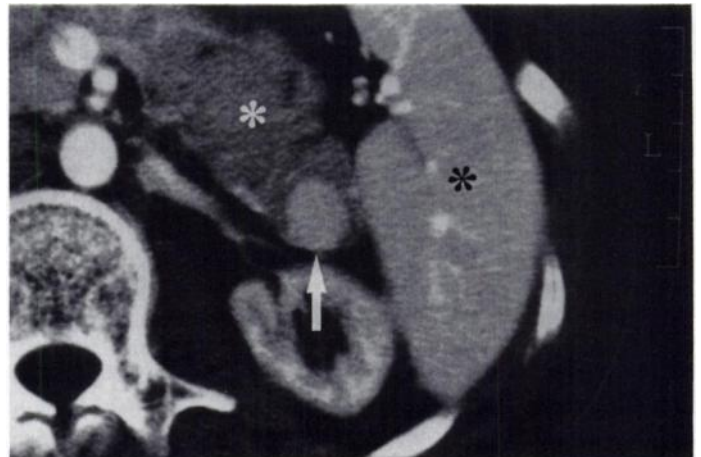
Arterial phase contrast-enhanced CT image of the IPAS. Mass (white arrow) is located in the tail of the pancreas (white asterisk). Mass density and structure are quite similar to those of the main spleen (black asterisk).
